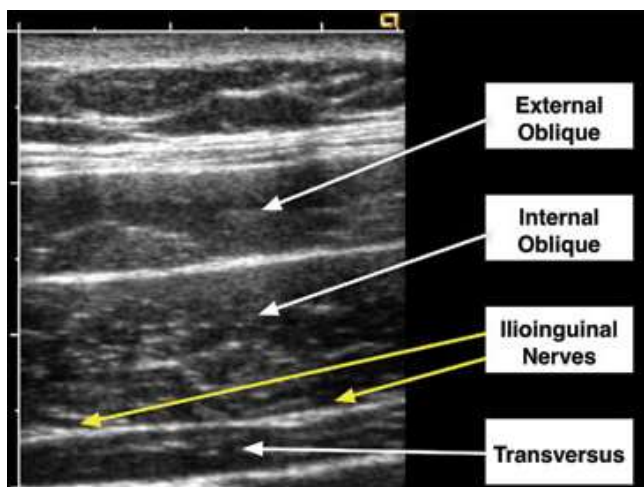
The transducer is correctly held in the line joining ASIS and the umbilicus, for the ultrasound guided ilio-inguinal nerve block. The ilio-inguinal nerve is visible resting superficial to the transversus abdominis muscle.
